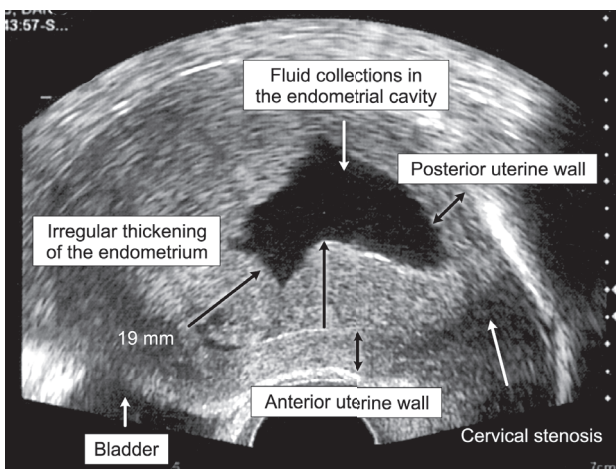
Endometrial carcinoma with cervical involvement, FIGO stage II. Total clinicosonographic score: 7.
